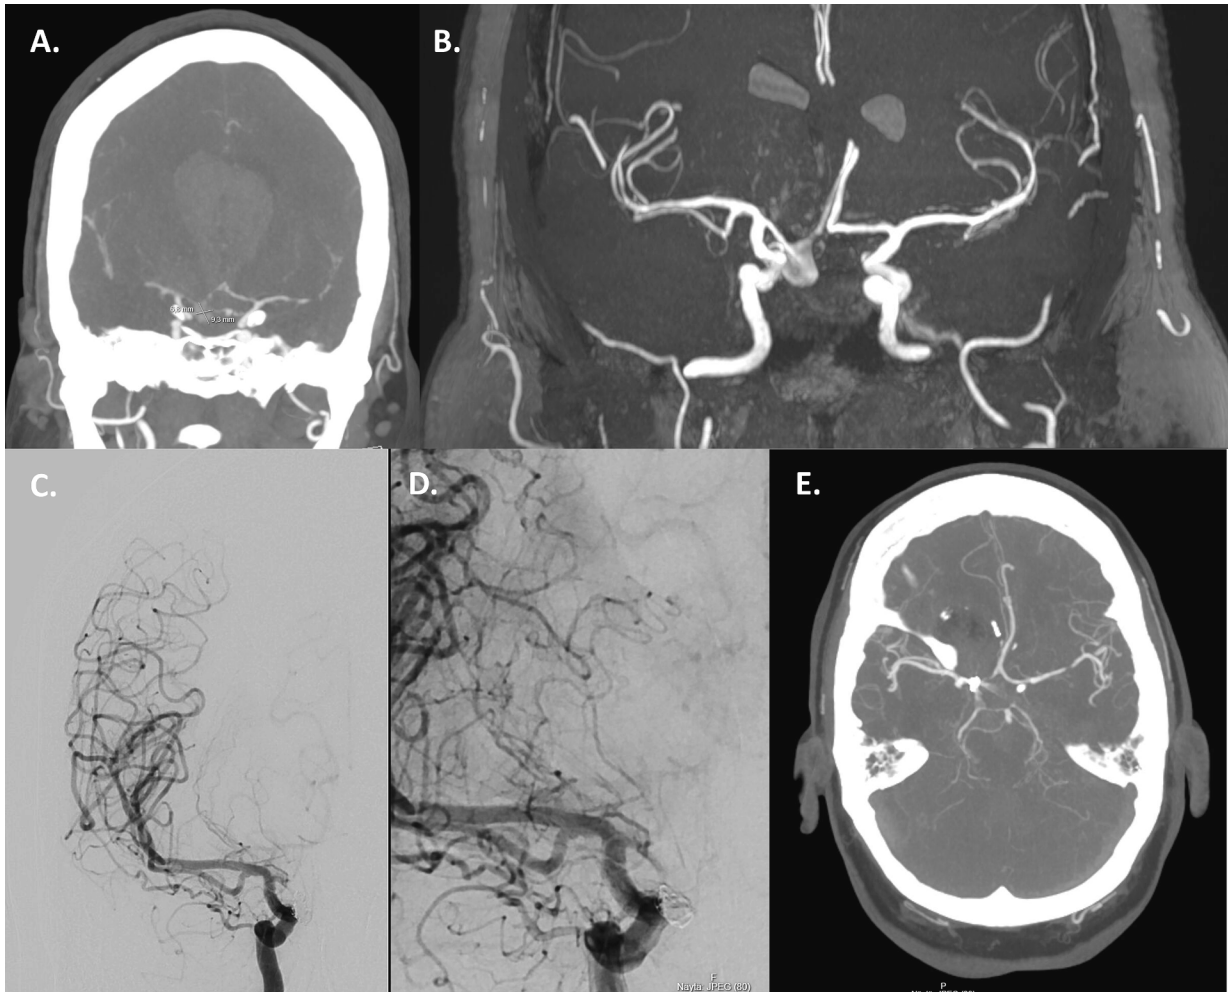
A., B. Coronal CTA and TOF MRI showing an aneurysmal subarachnoid haemorrhage (SAH) with intraventricular blood collection and hydrocephalus related to a A1 aneurysm rupture B. C., D.: DSA in sagittal angiogram with intracarotid contrast showing the aneurysmal coiling. D: CTA in axial view showing the coiled aneurysm.
